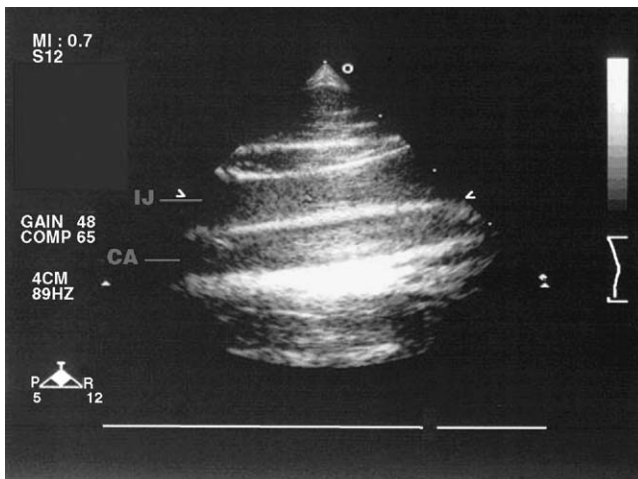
Long axis two-dimensional ultrasonogram of neck at the level of the cricoid. Probe is in the oblique plane. IJ, internal jugular vein; CA, carotid artery.
